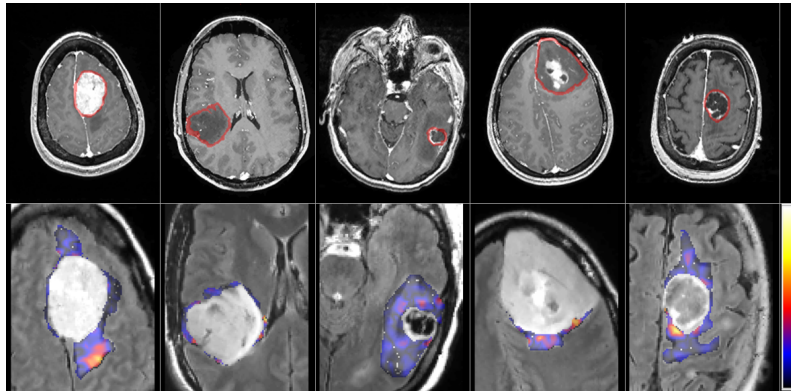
MR images of different of brain tumor types and an example of a texture pattern extracted from FLAIR in the edematous area. From left to right: meningioma, glioma grade II, grade III, grade IV and metastasis. 1st row: T1ce image with the tumoral ROI. 2nd row: FLAIR image (zoomed in the tumor region) overlaid with one of the textural patterns ($\lambda = 8$). The average texture values (calculated before FFT) proved to be significant in discrimination of meningiomas.
